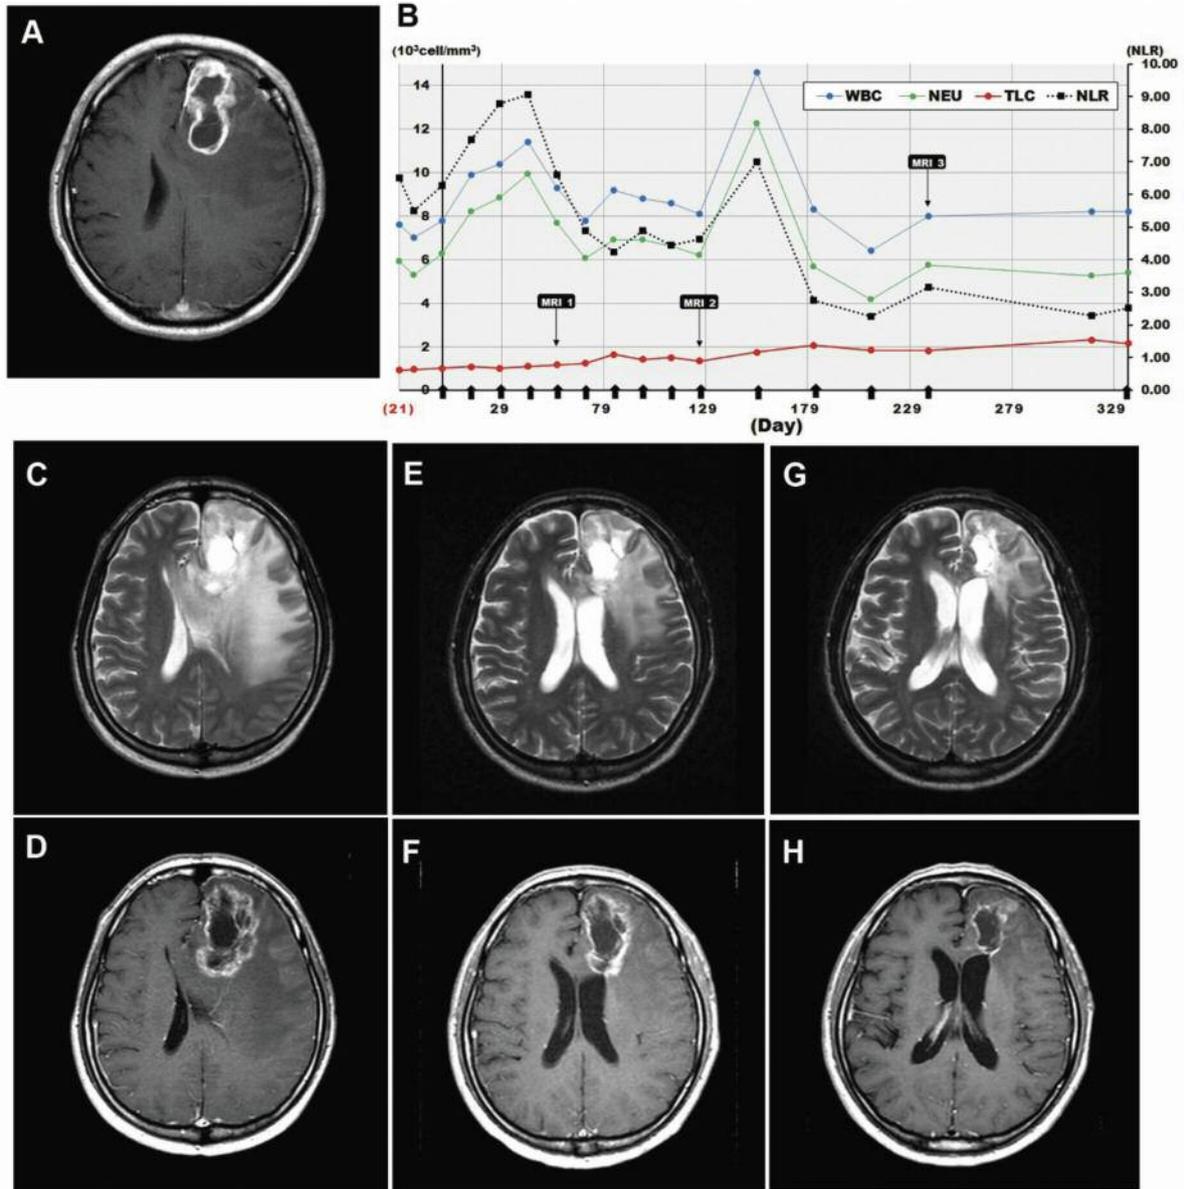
Clinical course of patient ONH-LAK24. Gd-enhanced magnetic resonance images before surgical resection (A) showed a Gd-enhanced lesion in the left frontal lobe. Line graph (B) shows the clinical course of the  $\alpha\beta$  T-cell immunotherapy. Black arrows on the x-axis indicate the time points of  $\alpha\beta$  T-cell injection. total white blood cell (WBC) count, neutrophil (NEU) count, and total lymphocyte count (TLC) during immunotherapy are shown using the left y-axis, neutrophil/lymphocyte ratio (NLR) is shown using the right y-axis. T2-Weighted (C, E, and G) and Gd-enhanced (D, F, and H) magnetic resonance images showed decreasing lesions at the 5th (C and D), 10th (E and F), 14th (G and H)  $\alpha\beta$  T-cell injection.
